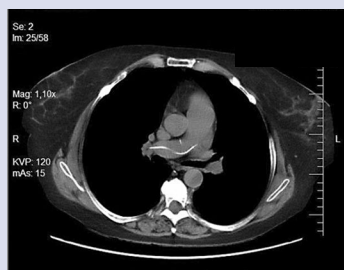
Chest computed tomography scan showing linear high attenuation shadow extending from the pulmonary trunk through the right pulmonary artery to its right upper branch
